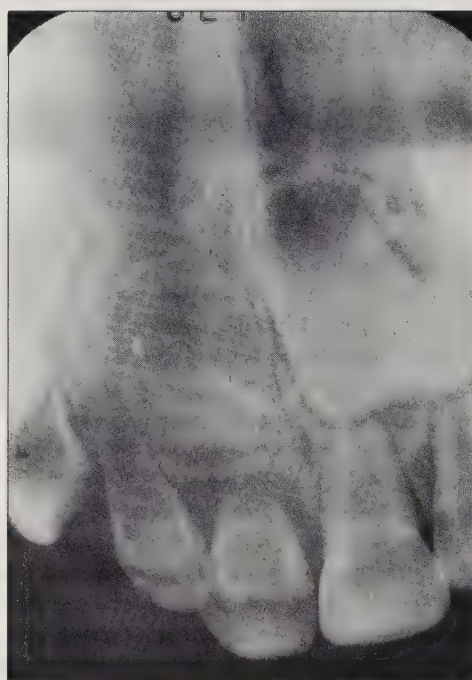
Anterior periapical view.
